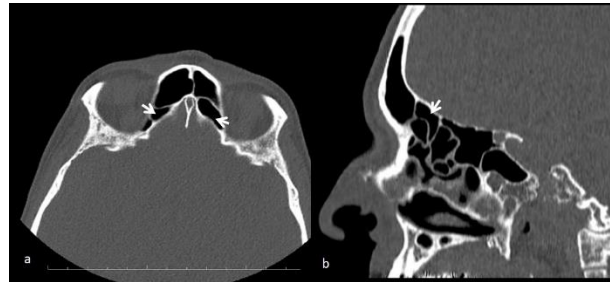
55-year-old man with bilateral supraorbital ethmoid cell. a, bilateral supraorbital ethmoid cell on paranasal BT (arrows): axial view b, left supraorbital ethmoid cell on paranasal CT (arrow): sagittal view.
